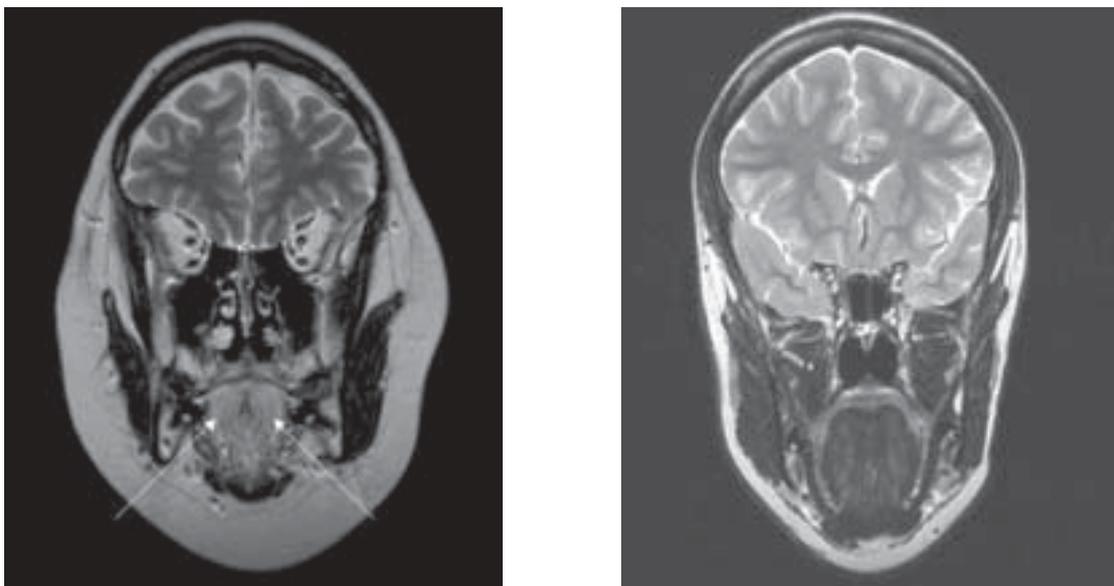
MR T2-weighted coronal sequences showing atrophy and fatty infiltration (high signal) in the tongue of case 2 (left), compared with normal appearance of healthy individual (right).
